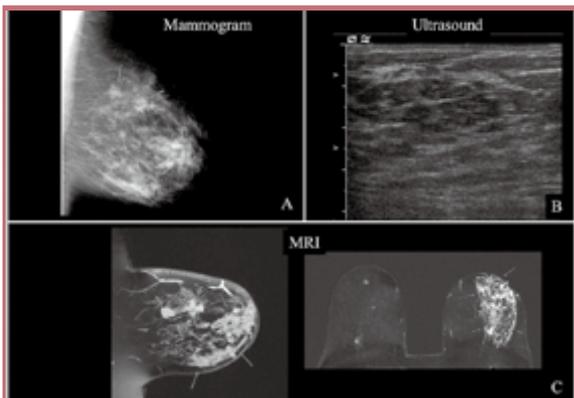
(A) Spiculated masses on mammogram MLO view only. Mammogram CC view normal (B) Ultrasound normal (C) MRI confirmed 2 spiculated masses proven to be carcinoma (arrowheads) & additional extensive DCIS which was mammographic & ultrasound occult (arrows)
